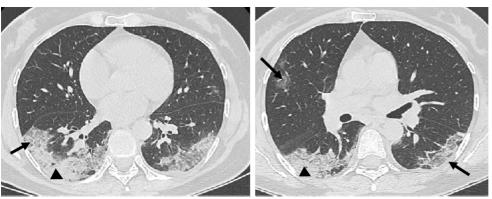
Axial computed tomography images show different patterns of ground glass opacities - round (red arrow), linear (arrowheads) and crazy paving (black arrow) with vascular enlargement (thick white arrow) within ground glass opacities areas.
